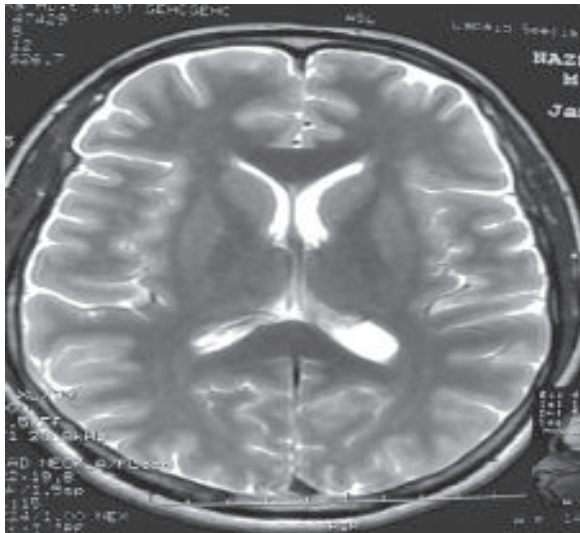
MRI of Brain revealed Normal.
